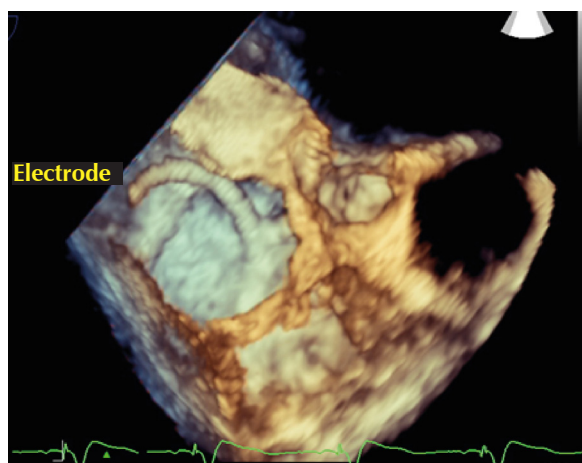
Three-dimensional transesophageal echocardiogram showing an implantable cardioverter defibrillator in the right atrium. The image belongs to a Chagas heart disease patient with high fever and positive blood cultures for *Staphylococcus aureus* without detectable cardiac vegetations.
